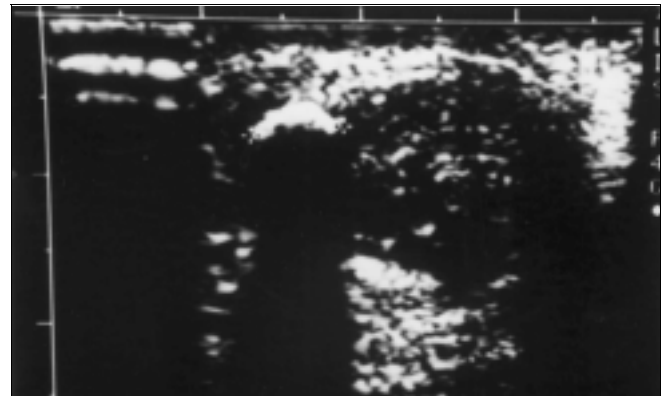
Longitudinal sonogram of the Achilles tendon demonstrating calcification in the tendon.
